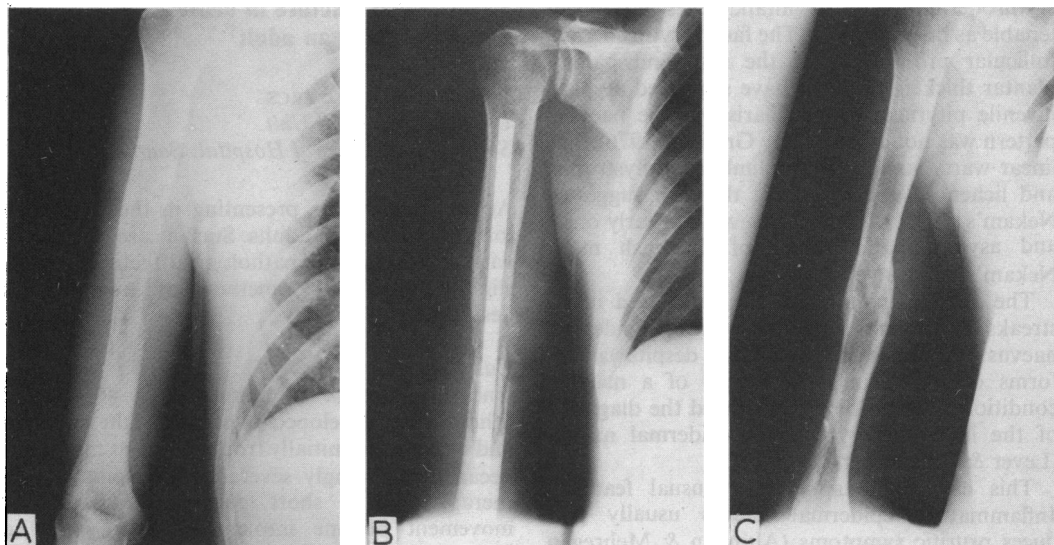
X-rays of the right humerus. A: on admission, showing an extensive osteolytic lesion of the mid-shaft. B: immediately postoperatively, showing the Kuntscher nail *in situ*; the edges of the fracture can also be seen. C: at 4 months, immediately after removal of the nail, showing that bony union has occurred
